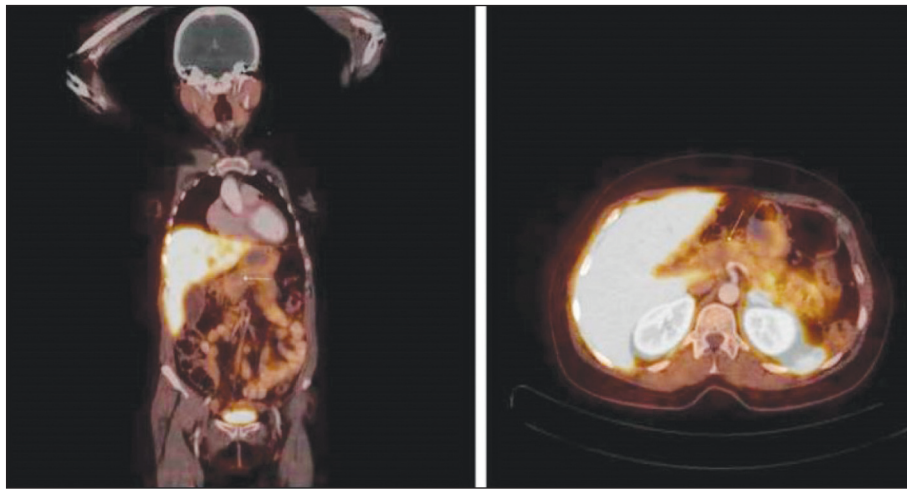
The GA-68 DOTATATE positron emission tomography-computed tomography scan results revealing a mass in the pancreas; coronal and transverse sections. DOTATATE: Tetra-azacyclo-dodecane-tetra-acetic acid-DPhe1-Tyr3-octreotate.
